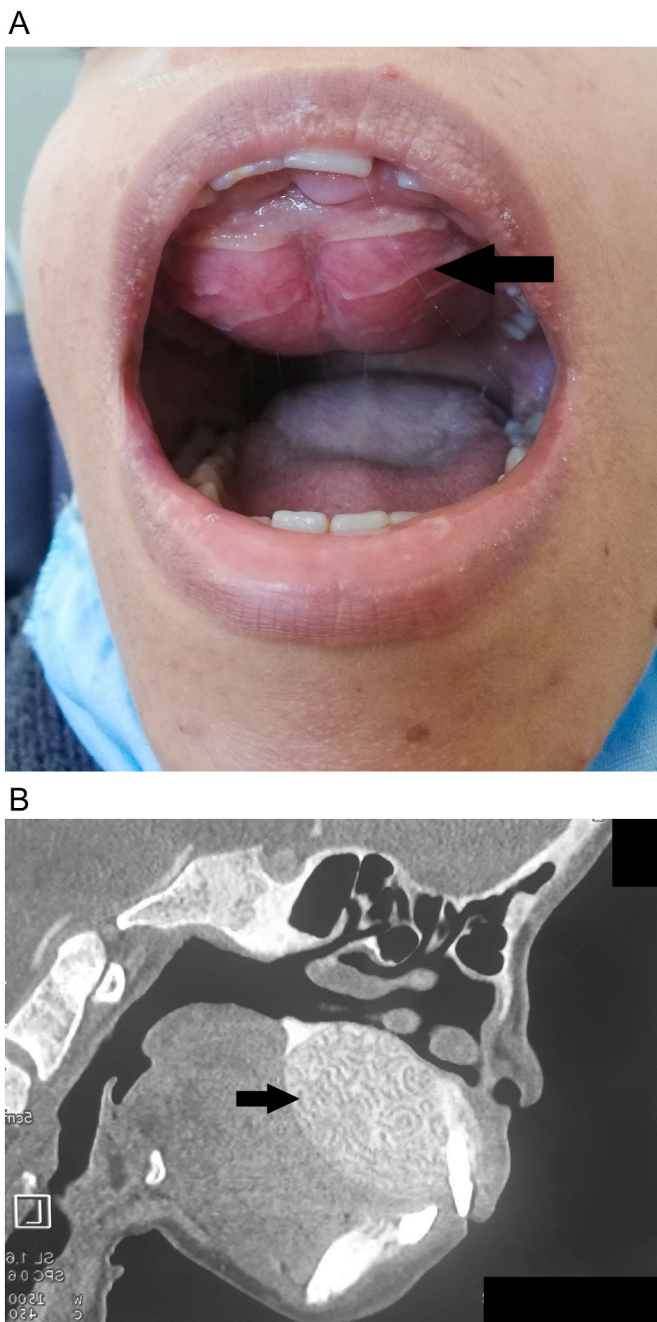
A (Above) palatal swelling(arrow) B (Below) Sagittal CT scan of palatal brown tumor with well-defined expanding osteolytic lesions (arrows).
